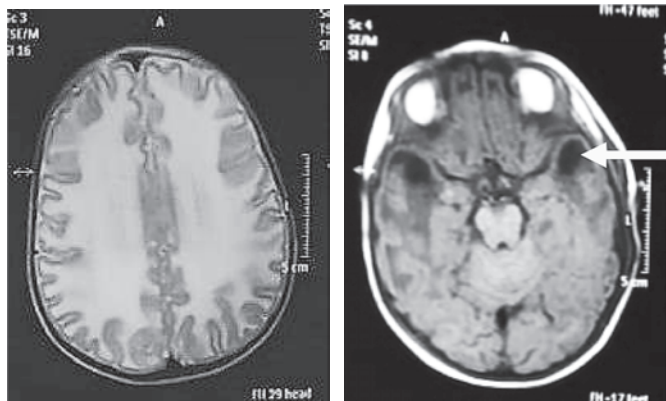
T2-weighted a&b MRI images of the brain show bilateral symmetrical diffuse white matter hyperintensity along with bilateral temporal cysts on FLAIR image.
